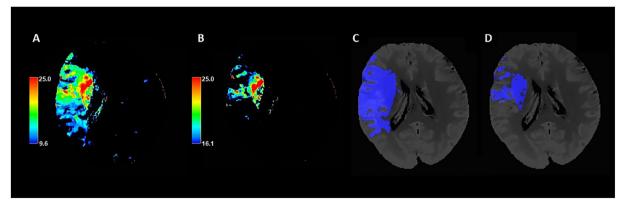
Automatic segmentation of critically hypoperfused tissue and infarct core volumes based on T_{max} >9.5seconds and >16 seconds threshold values. Panel A: Color coded CTP T_{max} map with scale set at 9.6 to 25 seconds. Panel B: Color coded CTP T_{max} map with scale set at 16.1 to 25 seconds. Panel C: T_{max} >9.5 seconds volume automatically segmented on CTP averaged images. Panel D: T_{max} >16 seconds volume automatically segmented on CTP averaged images. CTP = computed tomography perfusion; T_{max} = time to maximum concentration.
